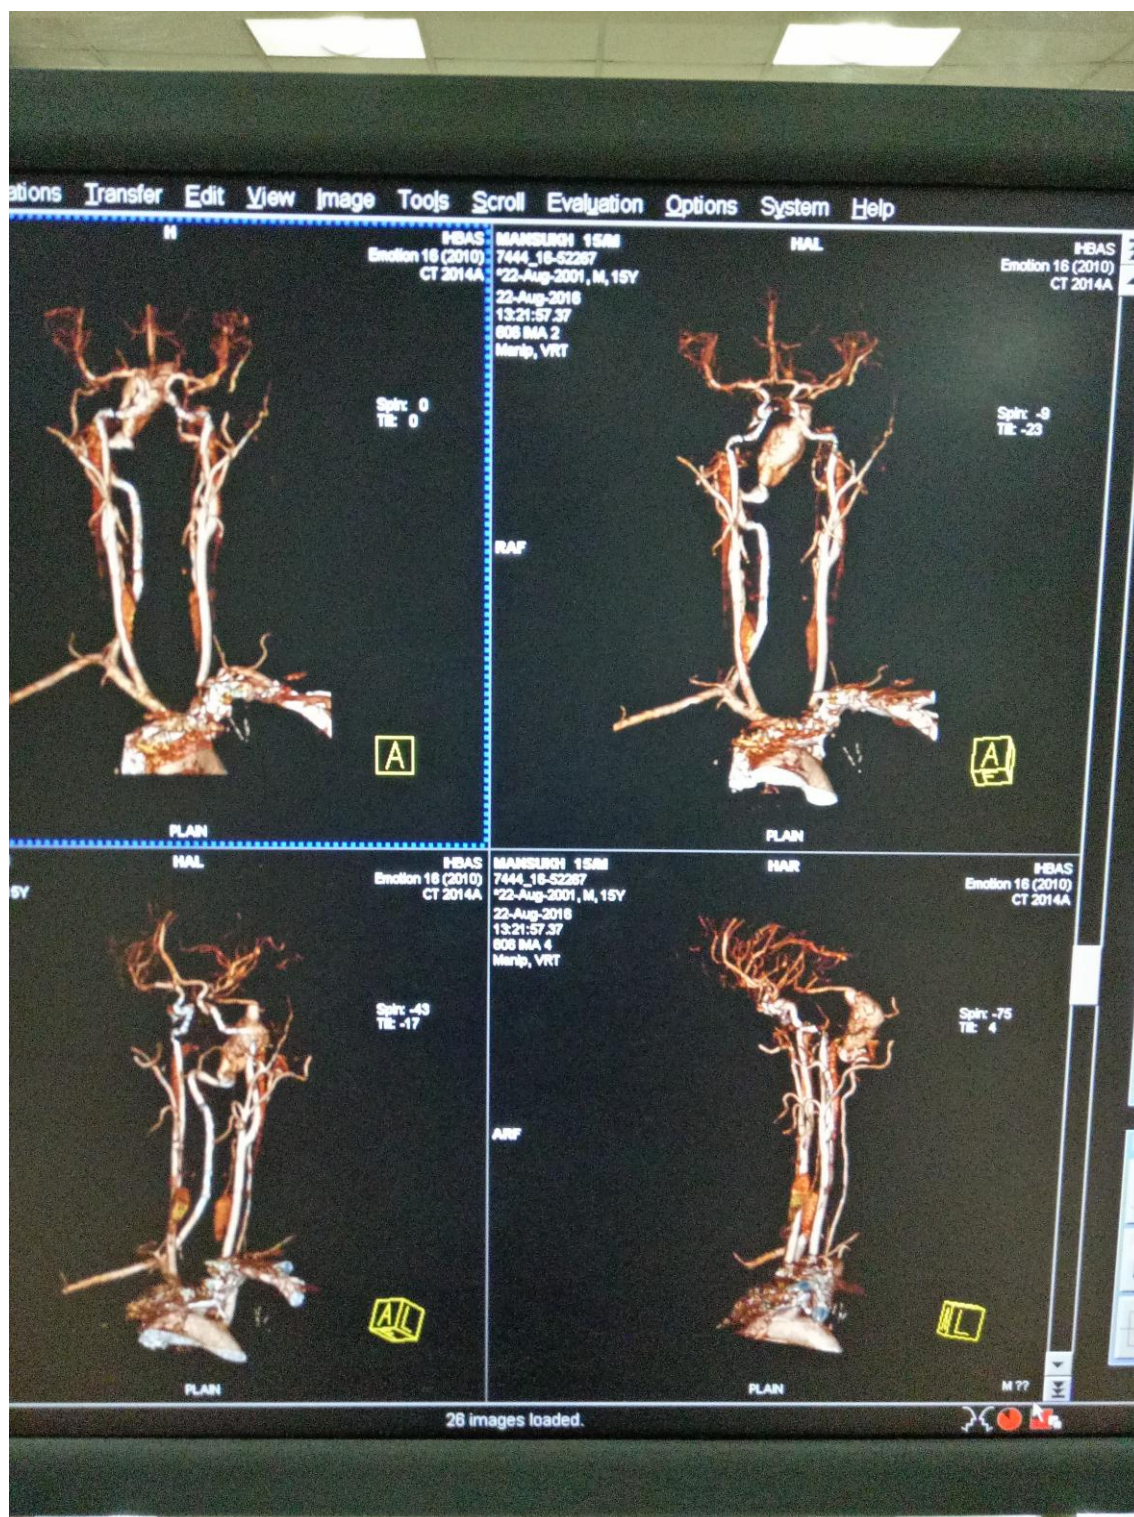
CT angiography of head and neck show a complex vertebral artery aneurysm involving the intradural segment (v4 segment) on the right side. There is also evidence of well defined peripheral crescent of increased attenuation within the thrombus of the large vertebral artery aneurysm suggestive of impending rupture of the same.
